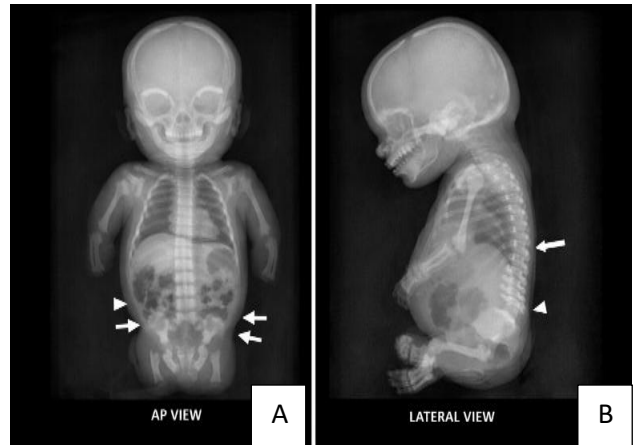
(A and B): X-ray of a 20-week abortus with CRS.
